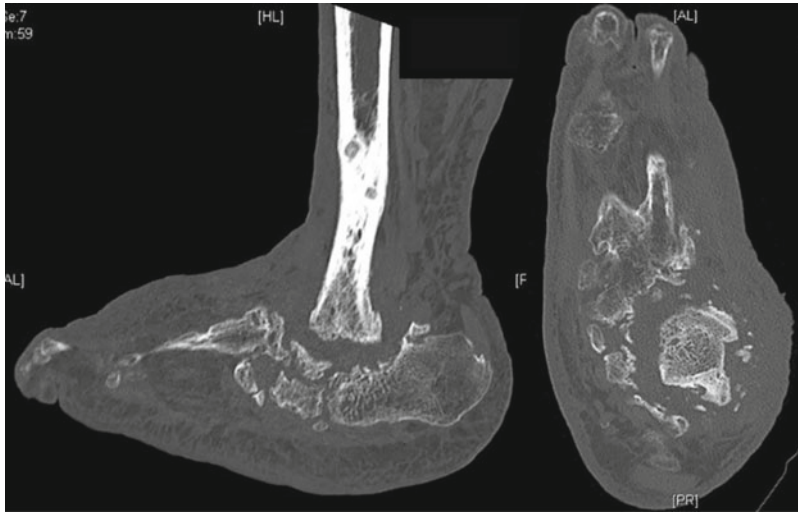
Computed tomography of a 63-year-old male patient presented with Charcot arthropathy (Case 17.4)
